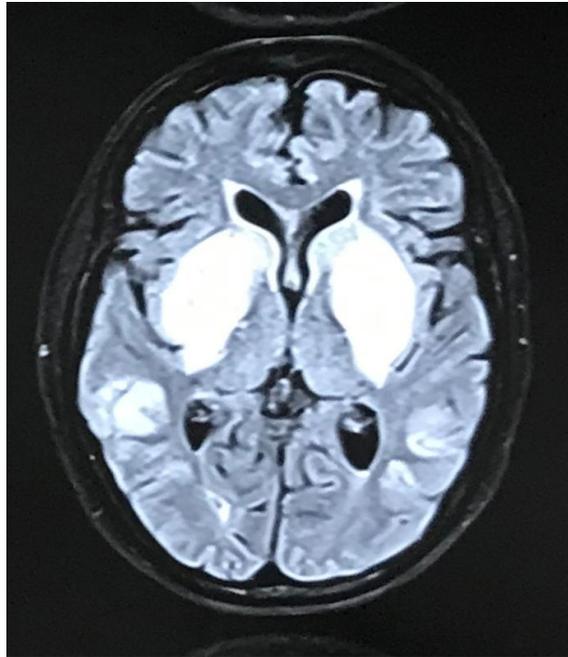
MRI brain FLAIR/T2 sequence showing bilateral basal ganglia and cortical hyperintensities.
